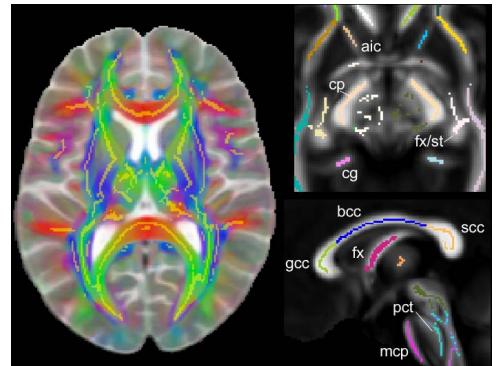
(Left) The IIT2 skeleton (in yellow), overlaid on the IIT2 FA-weighted color map, as well as the T2-weighted map of the ICBM152 template. (Right) Slices through the IIT2 skeletonized atlas.
